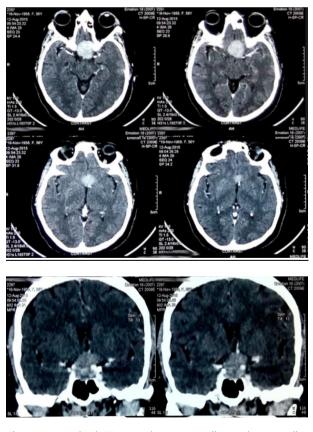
Cerebral CT scan showing a sellar and suprasellar contrast enhanced tumor.
